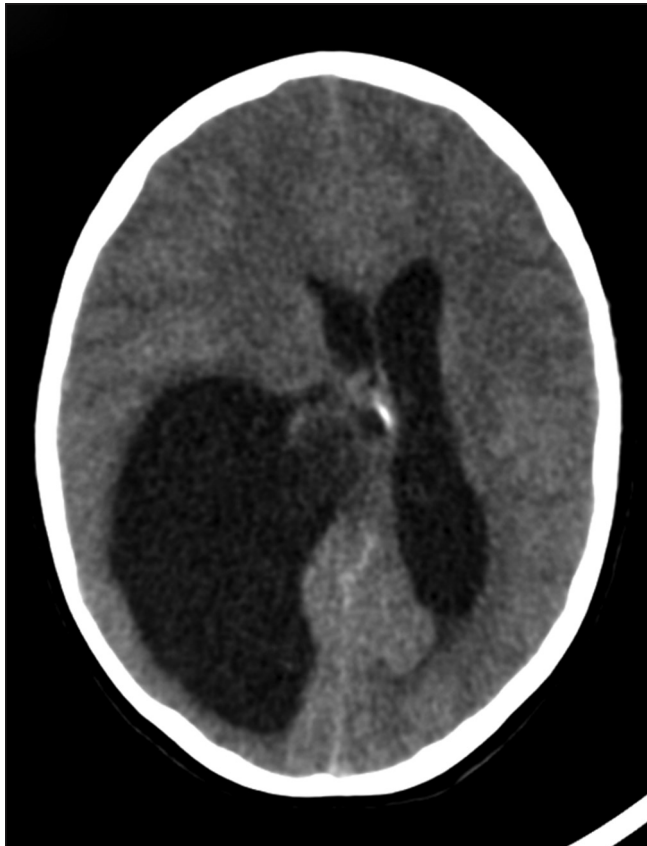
CT reveals a lesion having a tiny speck of calcification in the body of right lateral ventricle. Asymmetric dilatation of the ipsilateral lateral ventricle is seen with an entrapped posterior body
